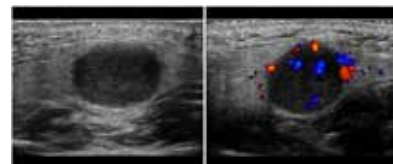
Ultrasound shows: Homogenous, solid, hypoechoic mass with sharp margins and no discrete posterior acoustic enhancement, Doppler shows a peripheral basket like pattern with fine branches extending to the centre suggestive of pleomorphic adenoma.
